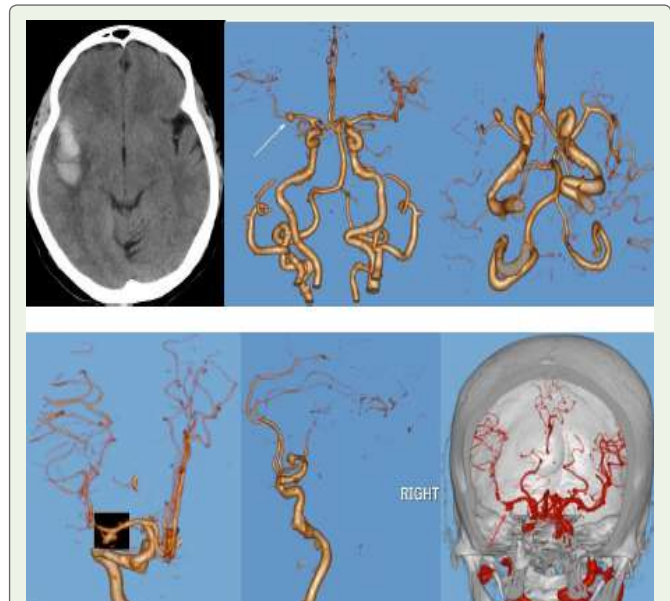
Right temporal lobe lobulated hematoma with surrounding edema is visible on CT axial non-contrast (A), whereas right MCA (M1) saccular aneurysm projecting inferiorly is visible on 3D-VR (B-E) and virtual dissection (F) images. Treated consecutively & on regular follow up.
